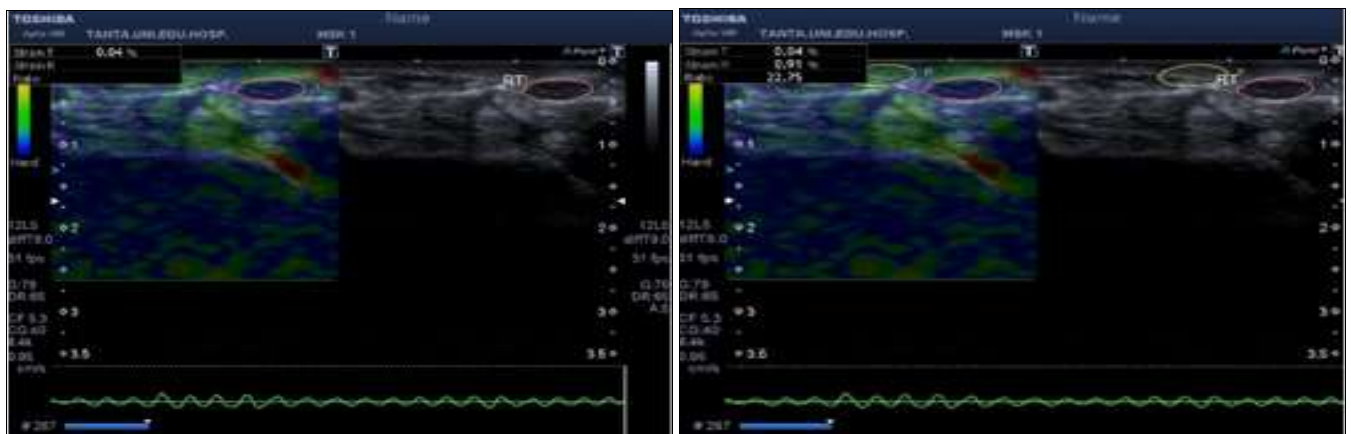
(A) Grey scale ultrasound showing right severe carpal tunnel syndrome and (B) Elastography ultrasound showing right severe carpal tunnel syndrome (Color map)
